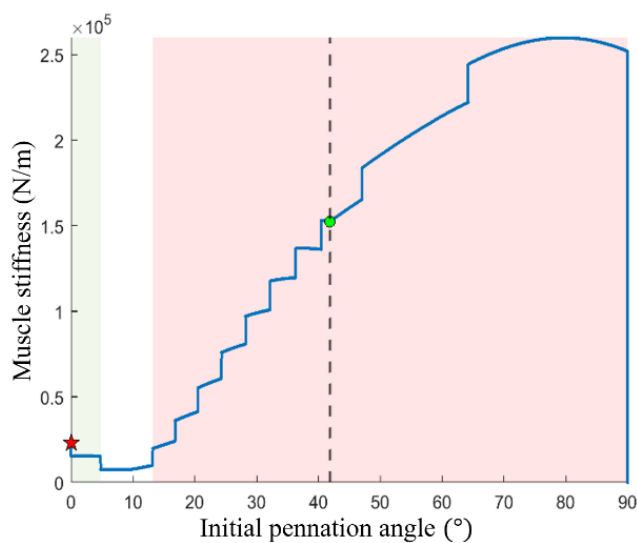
MUSCLE STIFFNESS AT BLOCKED FORCE WITH RESPECT TO INITIAL PENNATION ANGLE
